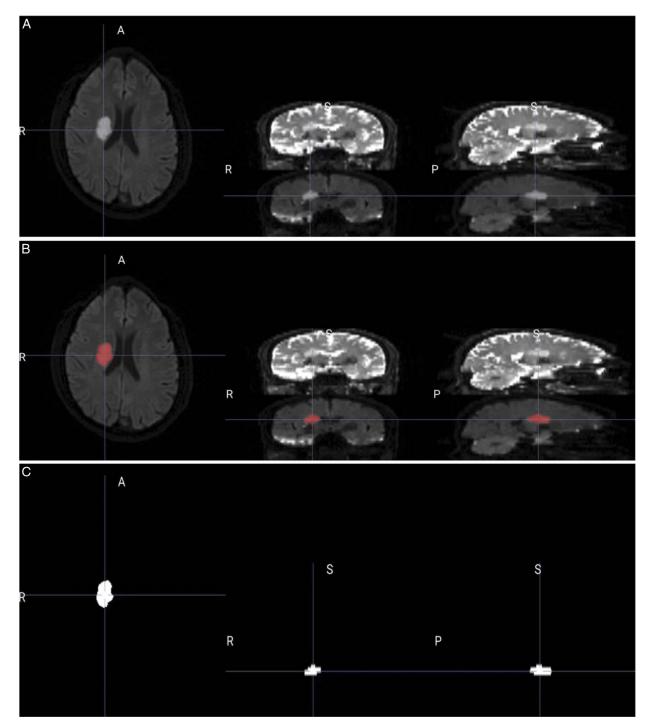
Lesion segmentation with MRIcroGL software. (A) A high signal lesion in the right coronal region on DWI images. (B) An ROI obtained by segmenting the high signal lesion on DWI images is shown in the red areas. (C) Obtained the ROI. DWI indicates diffusion-weighted imaging; ROI, region of interest.
